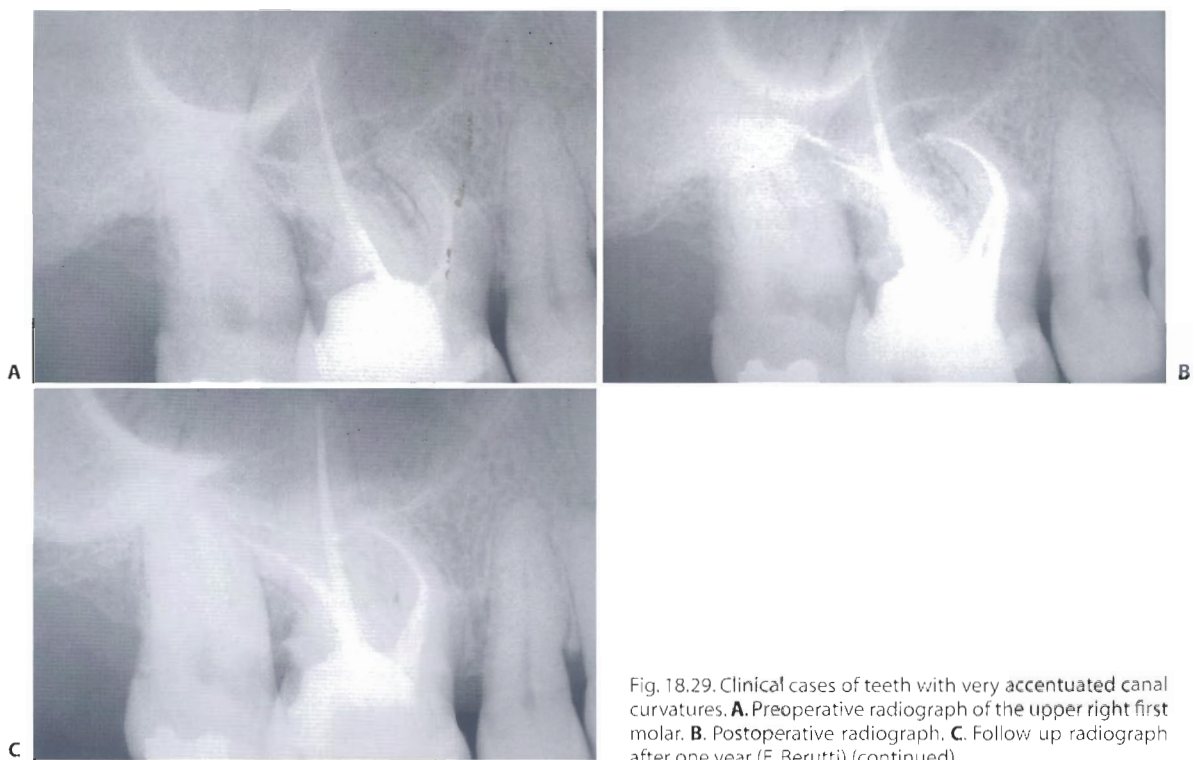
Clinical cases of teeth with very accentuated canal curvatures. A. Preoperative radiograph of the upper right first molar. B. Postoperative radiograph. C. Follow up radiograph after one year (E. Berutti) (continued).
